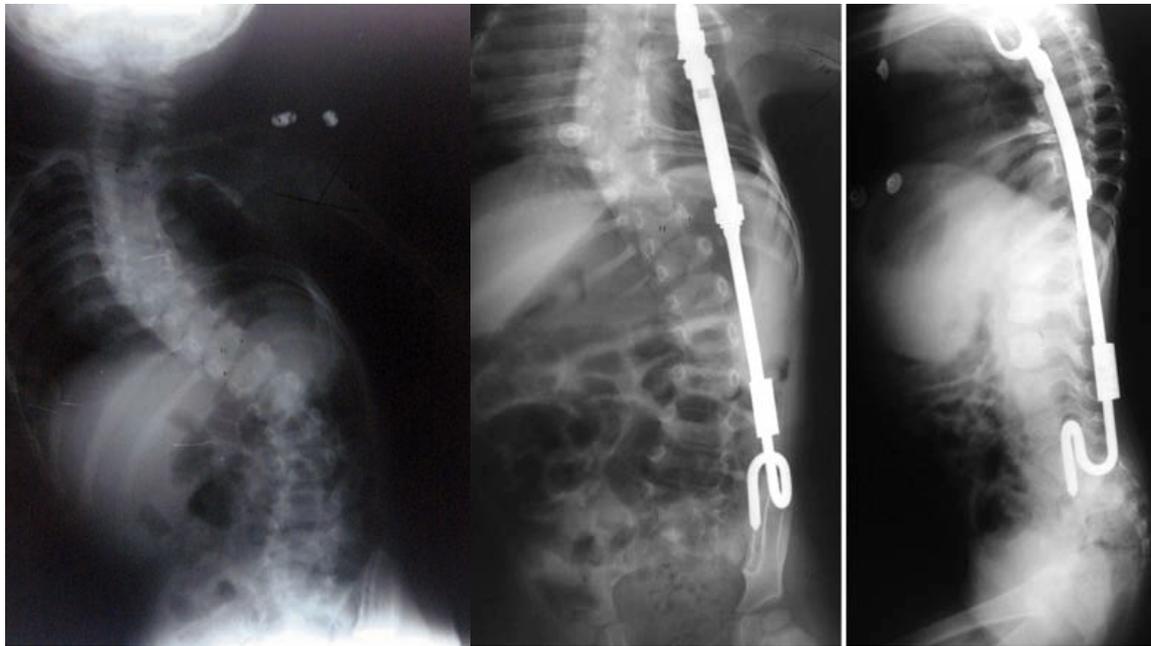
a. Anterior-posterior X-ray of the patient before surgery, b. Anterior-posterior and lateral X-rays after surgery, c. and d. anterior-posterior and lateral X-rays in the advanced follow-up period, e. the patient before surgery and f. the same patient after the advanced follow-up period.
